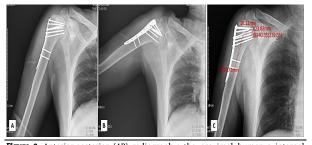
Anterior-posterior (AP) radiography; the proximal humerus internal locking system (PHILOS) plate, and calcar screws have been inserted through the deltopectoral approach; A) shoulder in adduction view; B) Shoulder in abduction view; C) Neck-shaft angle of 140.35
